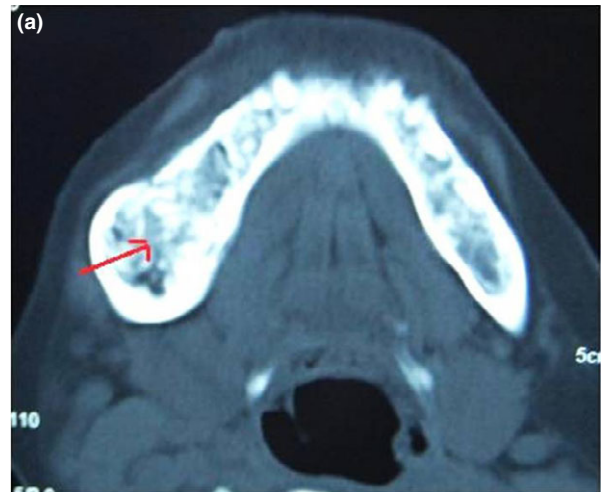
Axial computed tomography scan showing ground glass appearance (a), and anteroposterior view of spine showing scoliosis (b).
